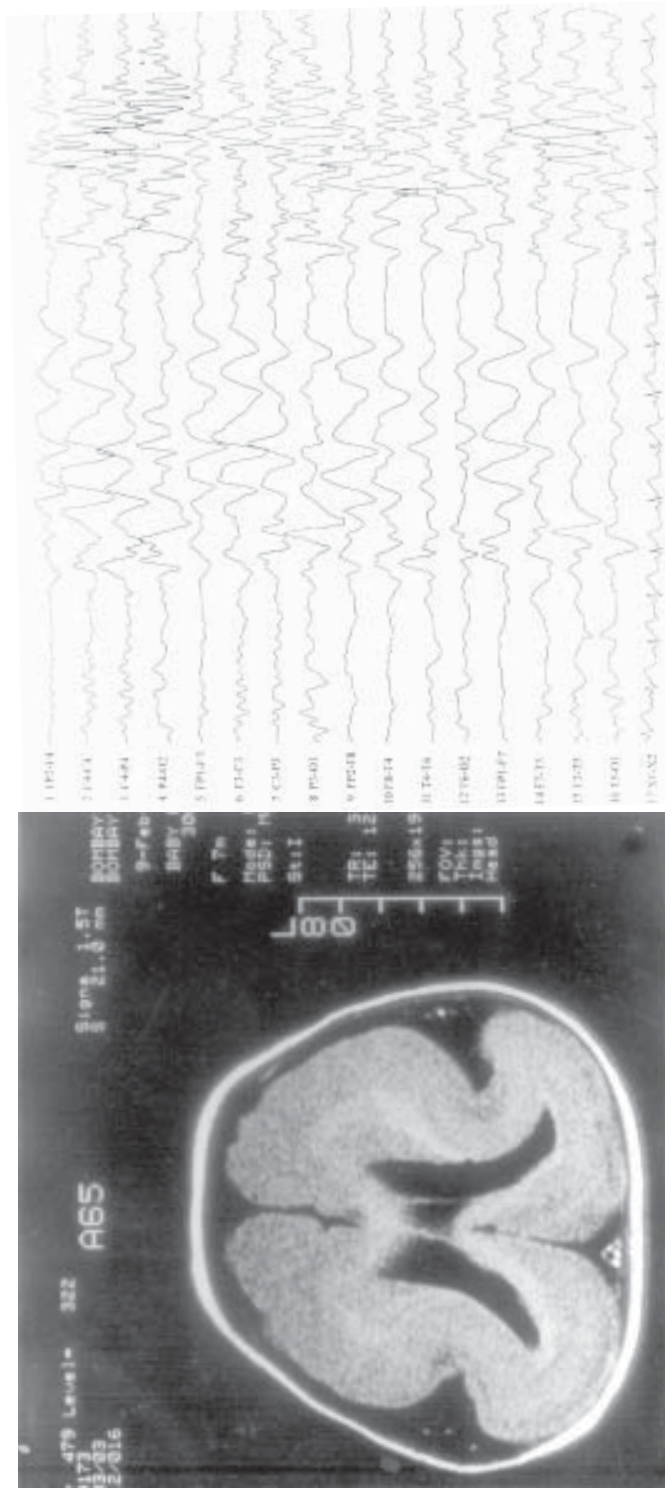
Type I Lissencephaly. Axial MR image showing the classic "figure 8" appearance and its EEG tracing showing high amplitude fast α and β activity with a mixture of high amplitude α and β rhythm.
